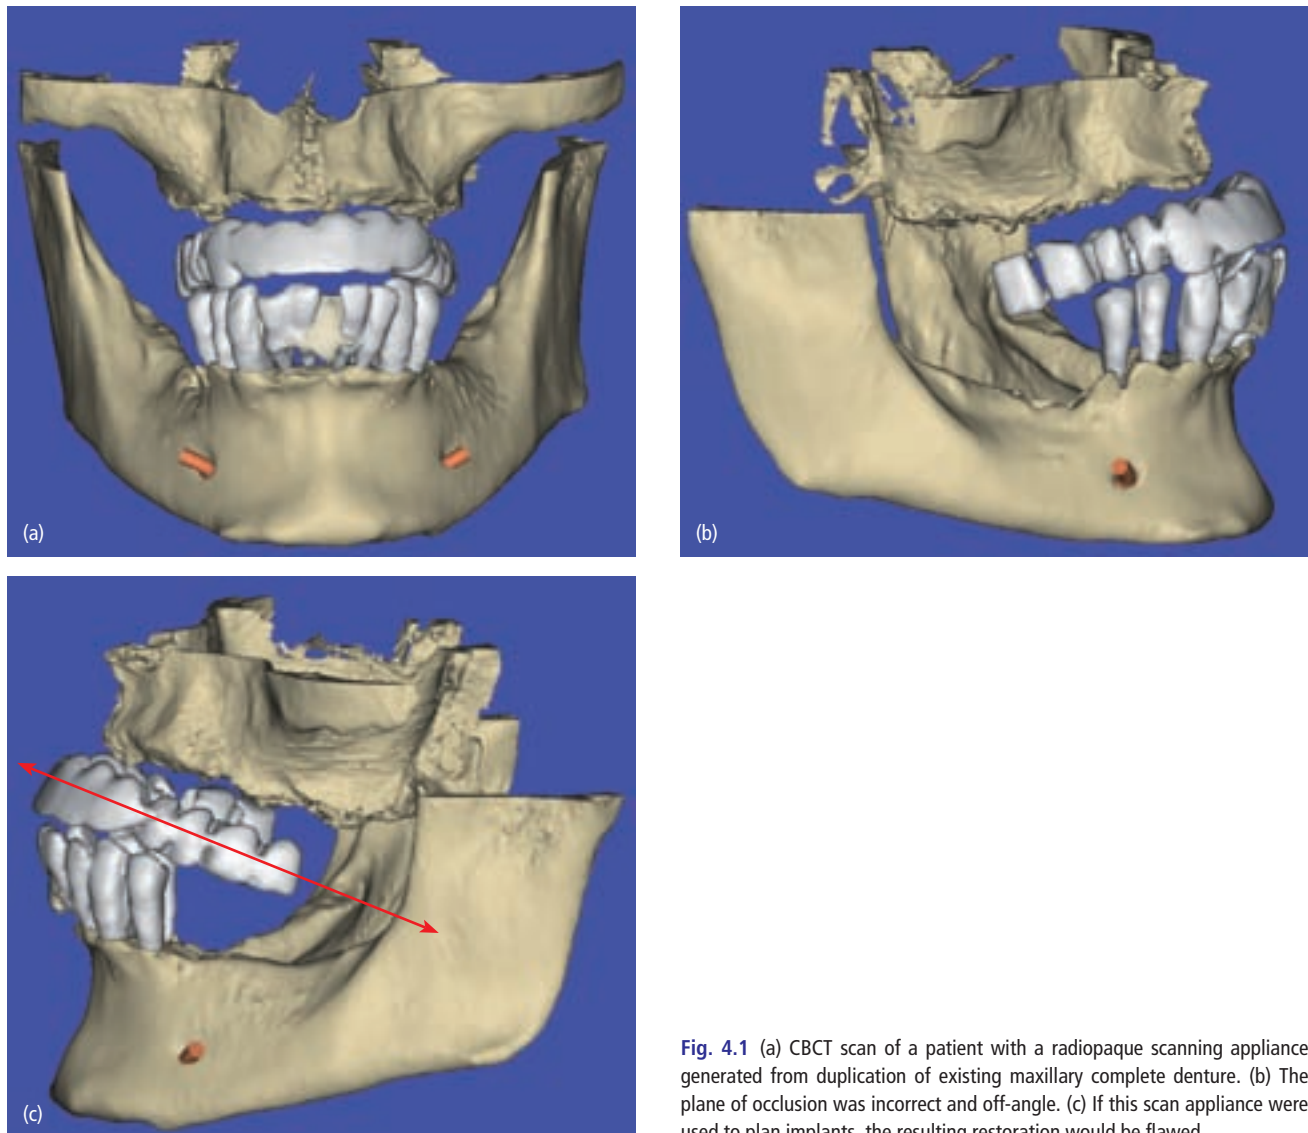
(a) CBCT scan of a patient with a radiopaque scanning appliance generated from duplication of existing maxillary complete denture. (b) The plane of occlusion was incorrect and off-angle. (c) If this scan appliance were used to plan implants, the resulting restoration would be flawed.
